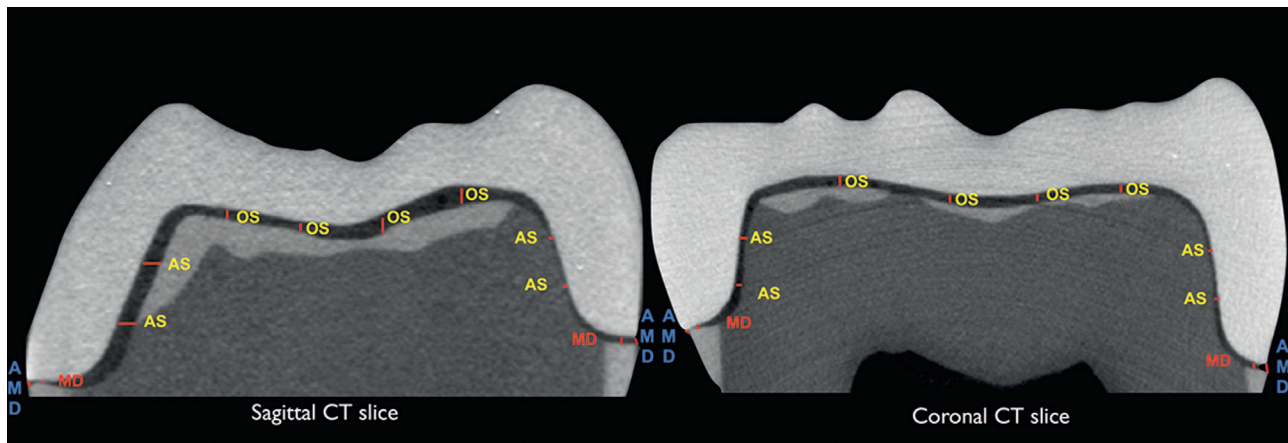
Sagittal and coronal cuts of microcomputed tomography scan image with measurement points for axial space (AS), occlusal space (OS), marginal discrepancy (MD), and absolute marginal discrepancy (AMD).
